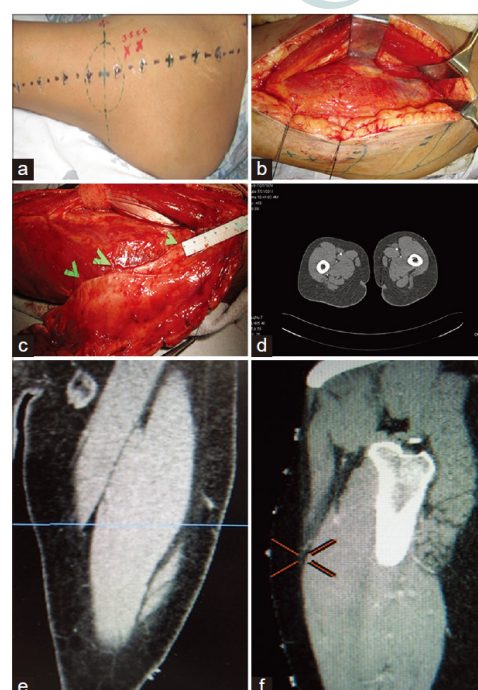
Case 4: (a) "X" denotes Doppler signal, "•" denotes MDCTA preoperative perforator localization; (b) plastic buttons at segments of thigh along AP line. Doppler signal at 3.5 cm and 5.5 cm above midpoint of AP line; (c) MDCTA axial section showing TBLCFAP; (d) sizable semi-septocutaneous perforator (TBLCFAP-ssc) 15 cm from ASIS and two other septocutaneous perforators DBLCFAP-s which correlated with preoperative MDCTA; (e) and (f) same TBLCFAP seen in coronal and sagittal sections. MDCTA: multi-detector row computed tomography angiography; TBLCFAP-ssc: semi-septocutaneous perforator arising from transverse branch of lateral circumflex femoral artery; DBLCFAP-s: septocutaneous perforator arising from descending branch of lateral circumflex femoral artery
